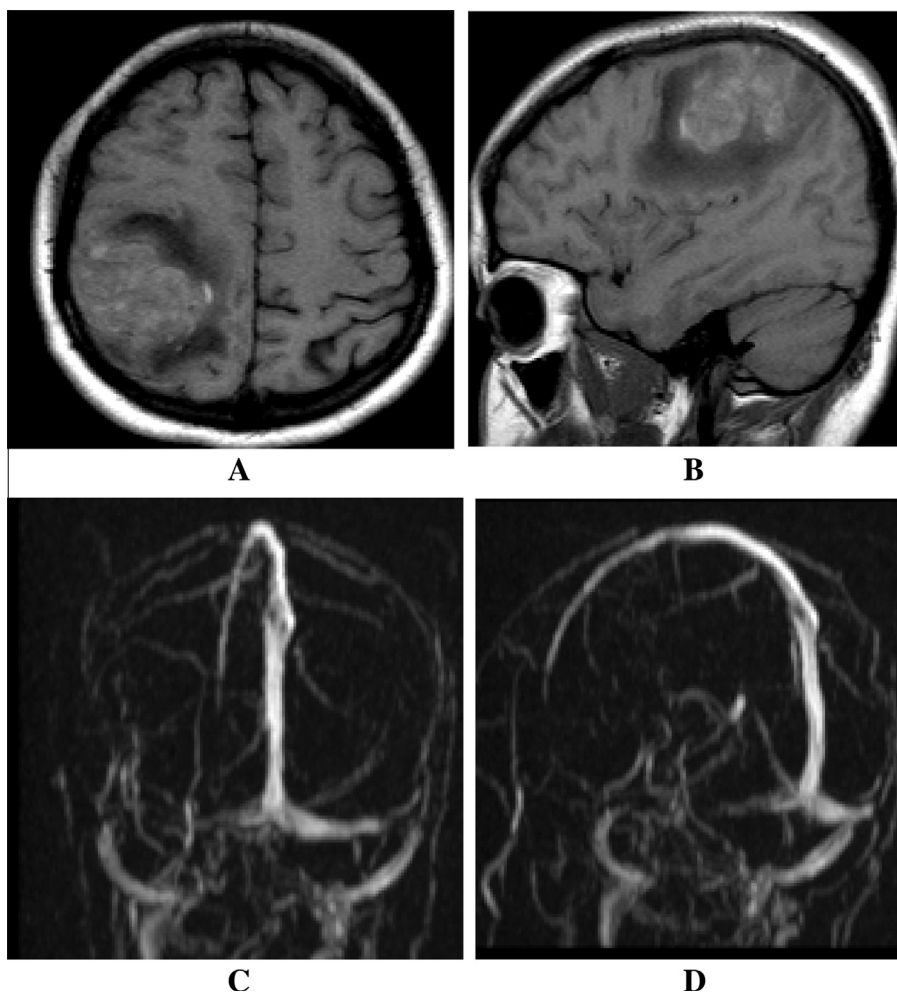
MRI T1w axial (A) and Sagittal (B) show right high parietal hemorrhagic infarction. MRV coronal (C) and Sagittal (D) reformat clearly show right transverse sinus thrombosis, supporting diagnosis of hemorrhagic venous infarct.
